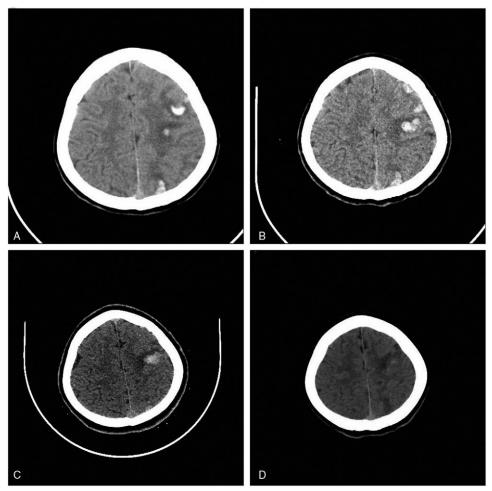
(A) Initial computed tomography (CT) showed intracerebral hemorrhages in the left frontal and parietal lobes. (B–D) Follow-up CT performed at 24 hours, 1 and 2 weeks after treatment initiation showed gradual resolution of the intracerebral hemorrhages, which were absorbed by 2 weeks.
